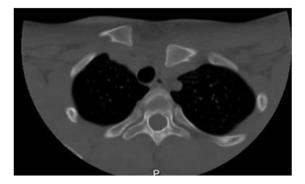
Axial CT scan taken 7 days after injury, again showing left posterior SC joint dislocation. *CT*, computed tomography; *SC*, sternoclavicular.
